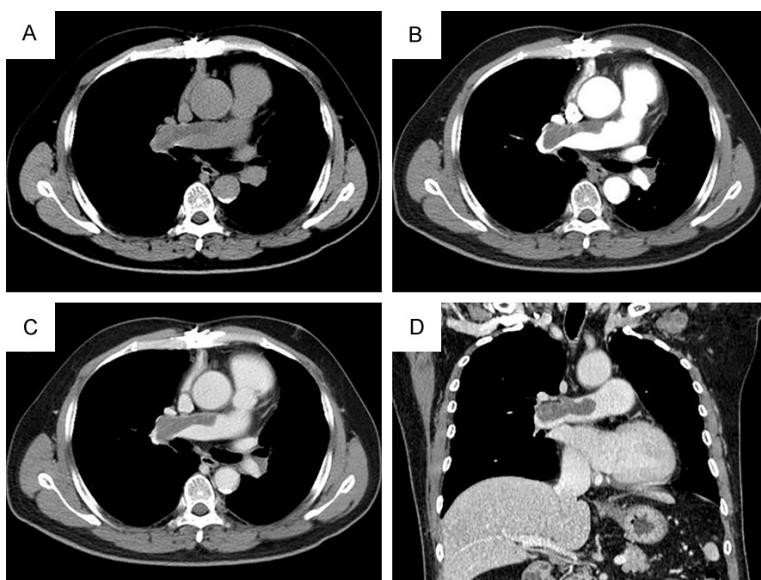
Computed tomography (CT) images of recurrence of pulmonary artery sarcoma after surgery. A. Plain axial image; B. Arterial phase axial image; C. Venous phase axial image; D. Venous phase coronal image.
